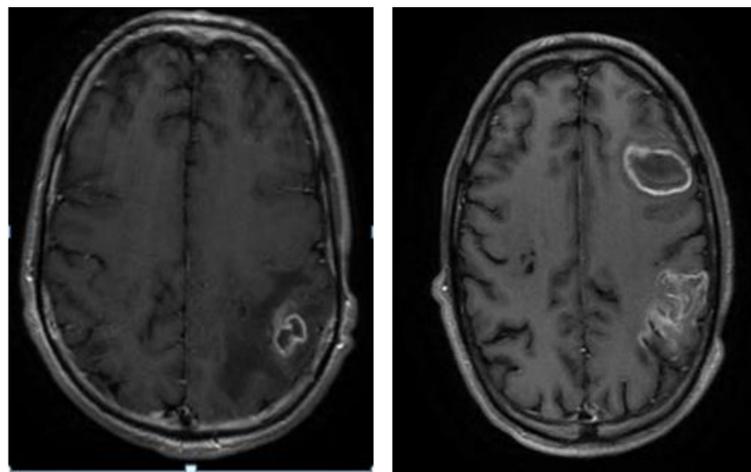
MRI scans from two IVDU patients with cerebral septic emboli
